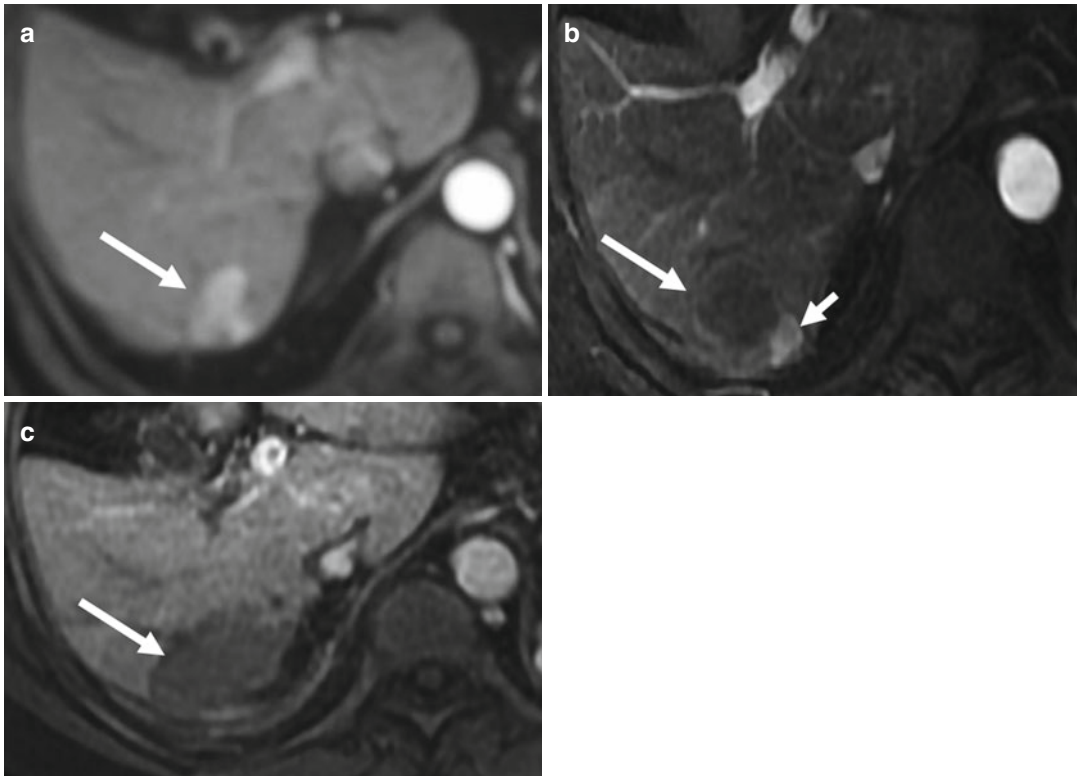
Transverse images in a 54-year-old man with a single focus of HCC (3.7×3.6 cm) and accompanying cirrhosis. (a) Contrast-enhanced MRI before ablation shows a hyperintense nodule adjacent to the diaphragm at arterial phase (arrow). (b) Contrast-enhanced MRI scan obtained
